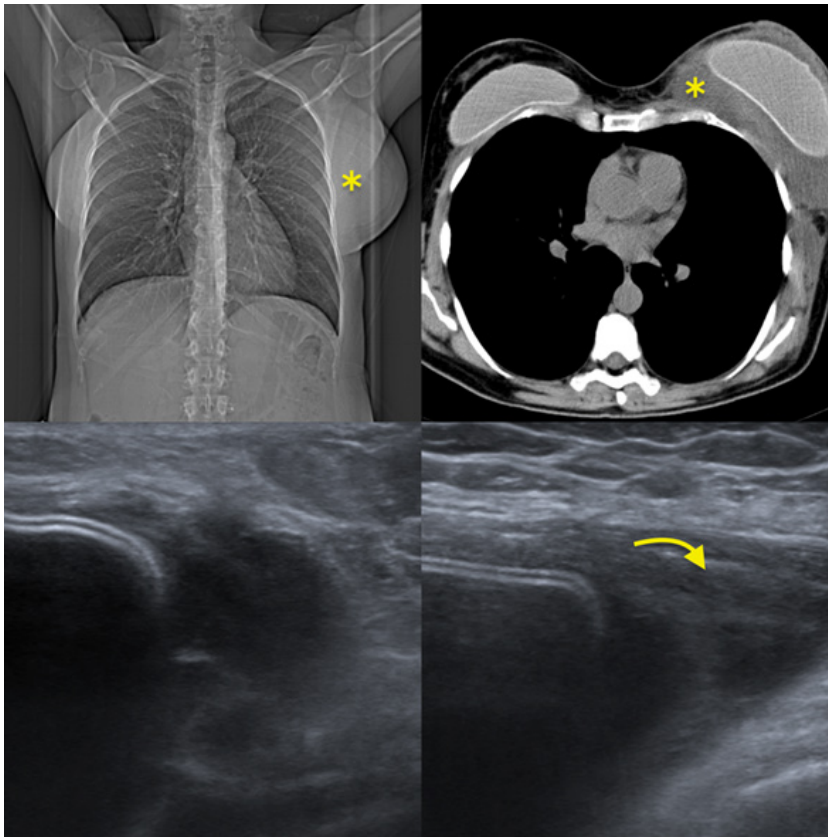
A 46-year-old female submitted to augmentation mammoplasty, with markedly developed breast asymmetry during the postoperative period. The tomodensitometric study revealed the presence of voluminous periprosthetic collection (asterisk), translated in the ultrasound study by multiseptated collection suggestive of hematoma. An eco-guided drainage of this hematoma was performed, with a favorable evolution of the clinical picture.
